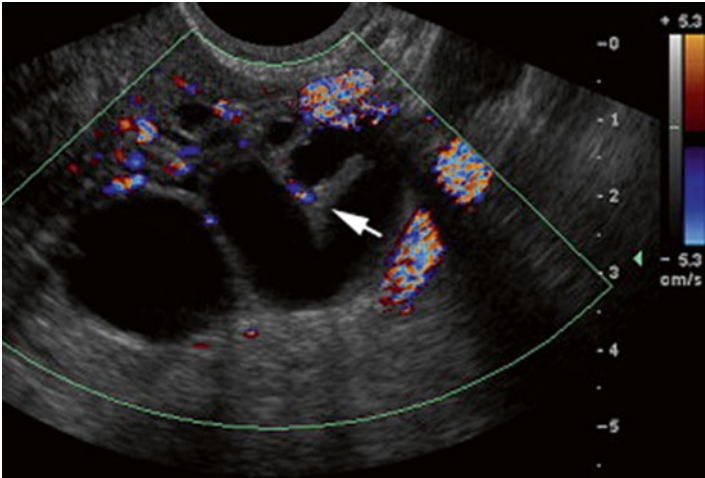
Hydrosalpinx. Color Doppler coronal image shows a serpiginous anechoic tubular structure in the adnexa. Real-time imaging helps differentiate this tubular structure from complex adnexal cystic mass. Note the incomplete septation sign (*arrow*) (Reprinted from Chu et al. [66], with permission from Elsevier)
